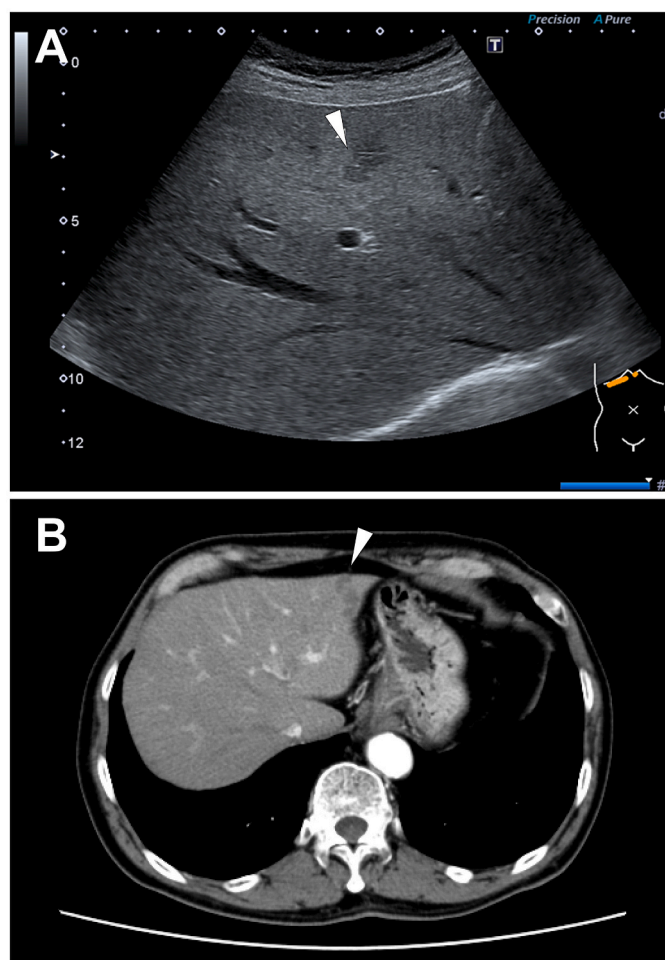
Abdominal images of the patient B-805. Ultrasonography [A], and enhanced CT [B] of the patient's hepatic lesion. Note areas which are hypoechoic in US and low density in CT.
